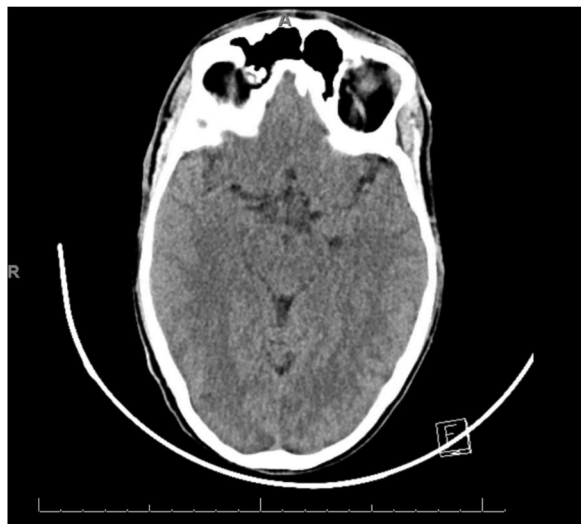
CT Head- Postoperative day 3, demonstrates loss of grey-white differentiation consistent with severe hypoxic brain injury.
